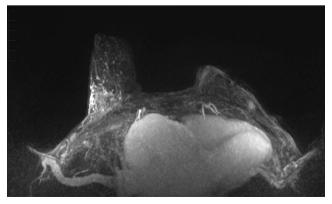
MRI: Post-contrast subtraction MIP image shows regional non-mass enhancement in the right upper outer quadrant measuring up to 3.8 cm, correlating with the site of biopsy.
